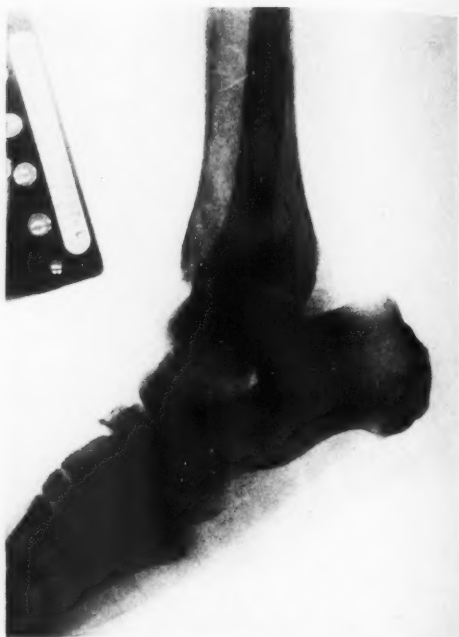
Roentgenogram of left os calcis taken for comparison with Figure 6-A (same case).
